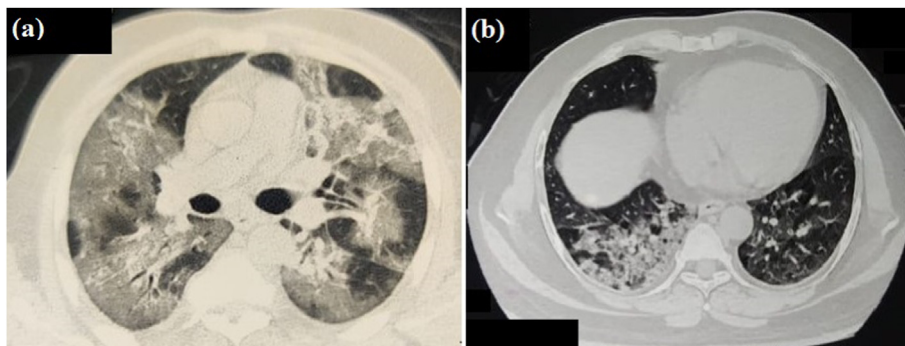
High resolution computed tomography (HRCT) thorax showing multiple patchy and confluent areas of ground glass opacities in both lungs (Panel a, b).
